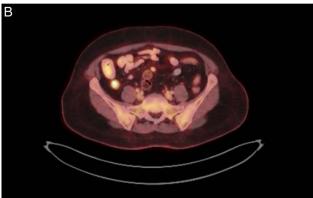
(A) High metabolic appendiceal uptake on coronal abdominal PET-computed tomography (CT) with [F18]-2-fluoro2-deoxy-d-glucose (FDG). (B) High metabolic appendiceal uptake on cross sectional abdominal PET-CT with FDG.
